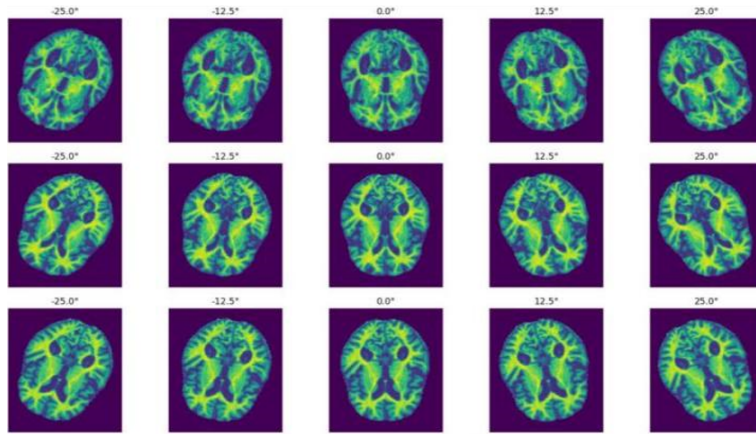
Data augmentation via rotational, translational, and elastic transformations applied to MRI scans.
